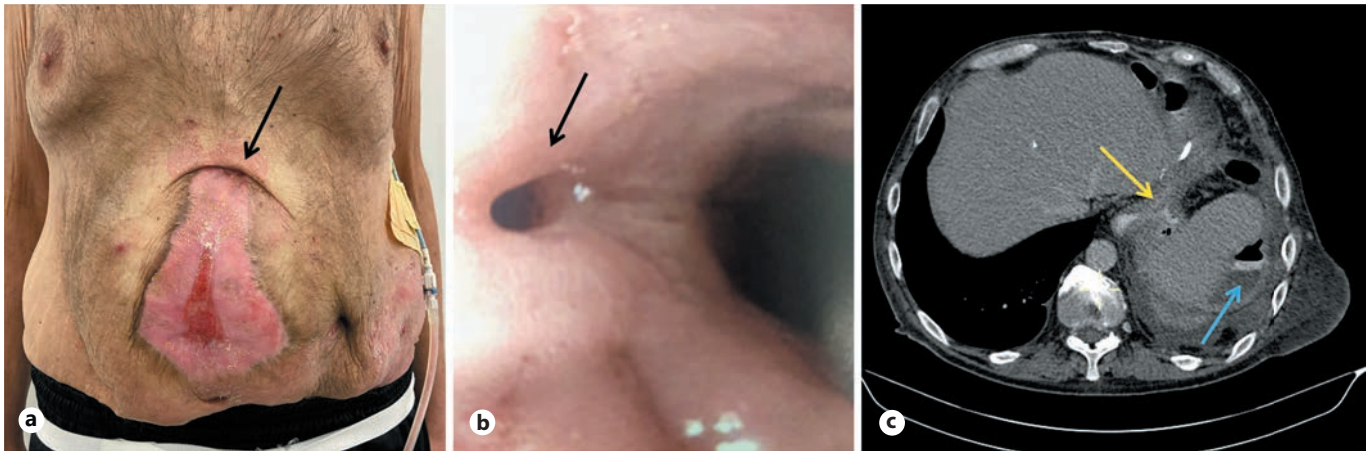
a Clinical photograph (arrow: cutaneous orifice of fistula; pigtail drain in left subphrenic abscess). b Endoscopic image of the fistula opening (arrow) below gastroesophageal junction. c CT scan: extravasation of oral contrast media (yellow arrow); left subphrenic abscess (blue arrow).
